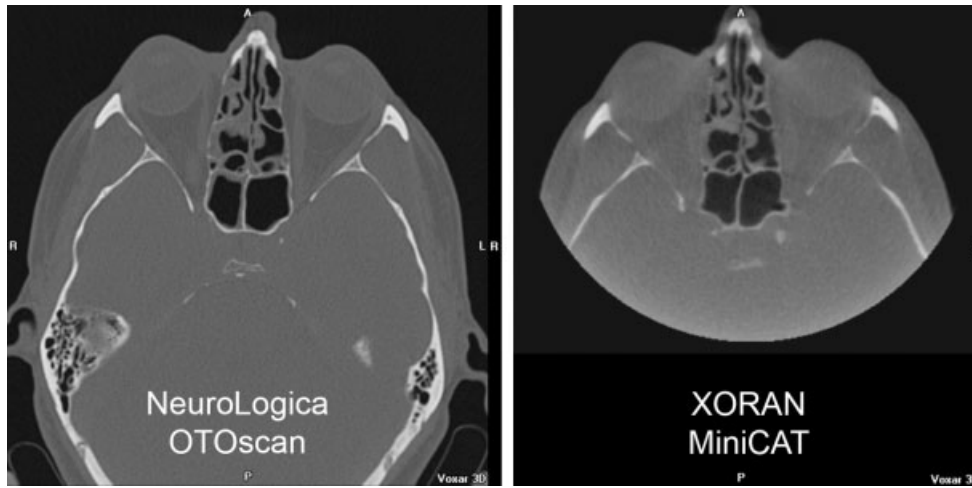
Comparison: Conventional scanner (MDCT) to flat panel scanner (CBCT). Head to head comparison of the NeuroLogica OTOScan conventional (MDCT) CT and the Xoran minicat flat panel scanner. This subject was scanned at the same 0.4 rad dose in each scanner. Images are set at window/level 4000/700. (These images are provided courtesy of Rob Smith, NeuroLogica.)
